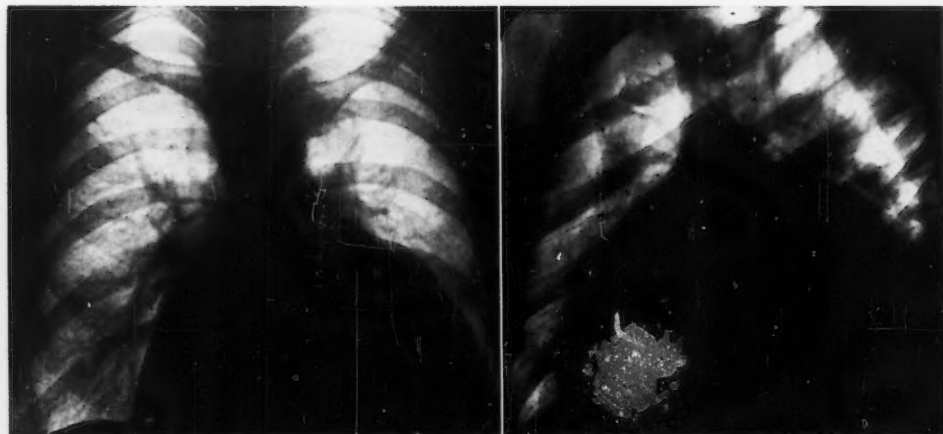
Case 1. *Left.* 1957, progressive heart dilatation. *Right.* X-ray left oblique position.
